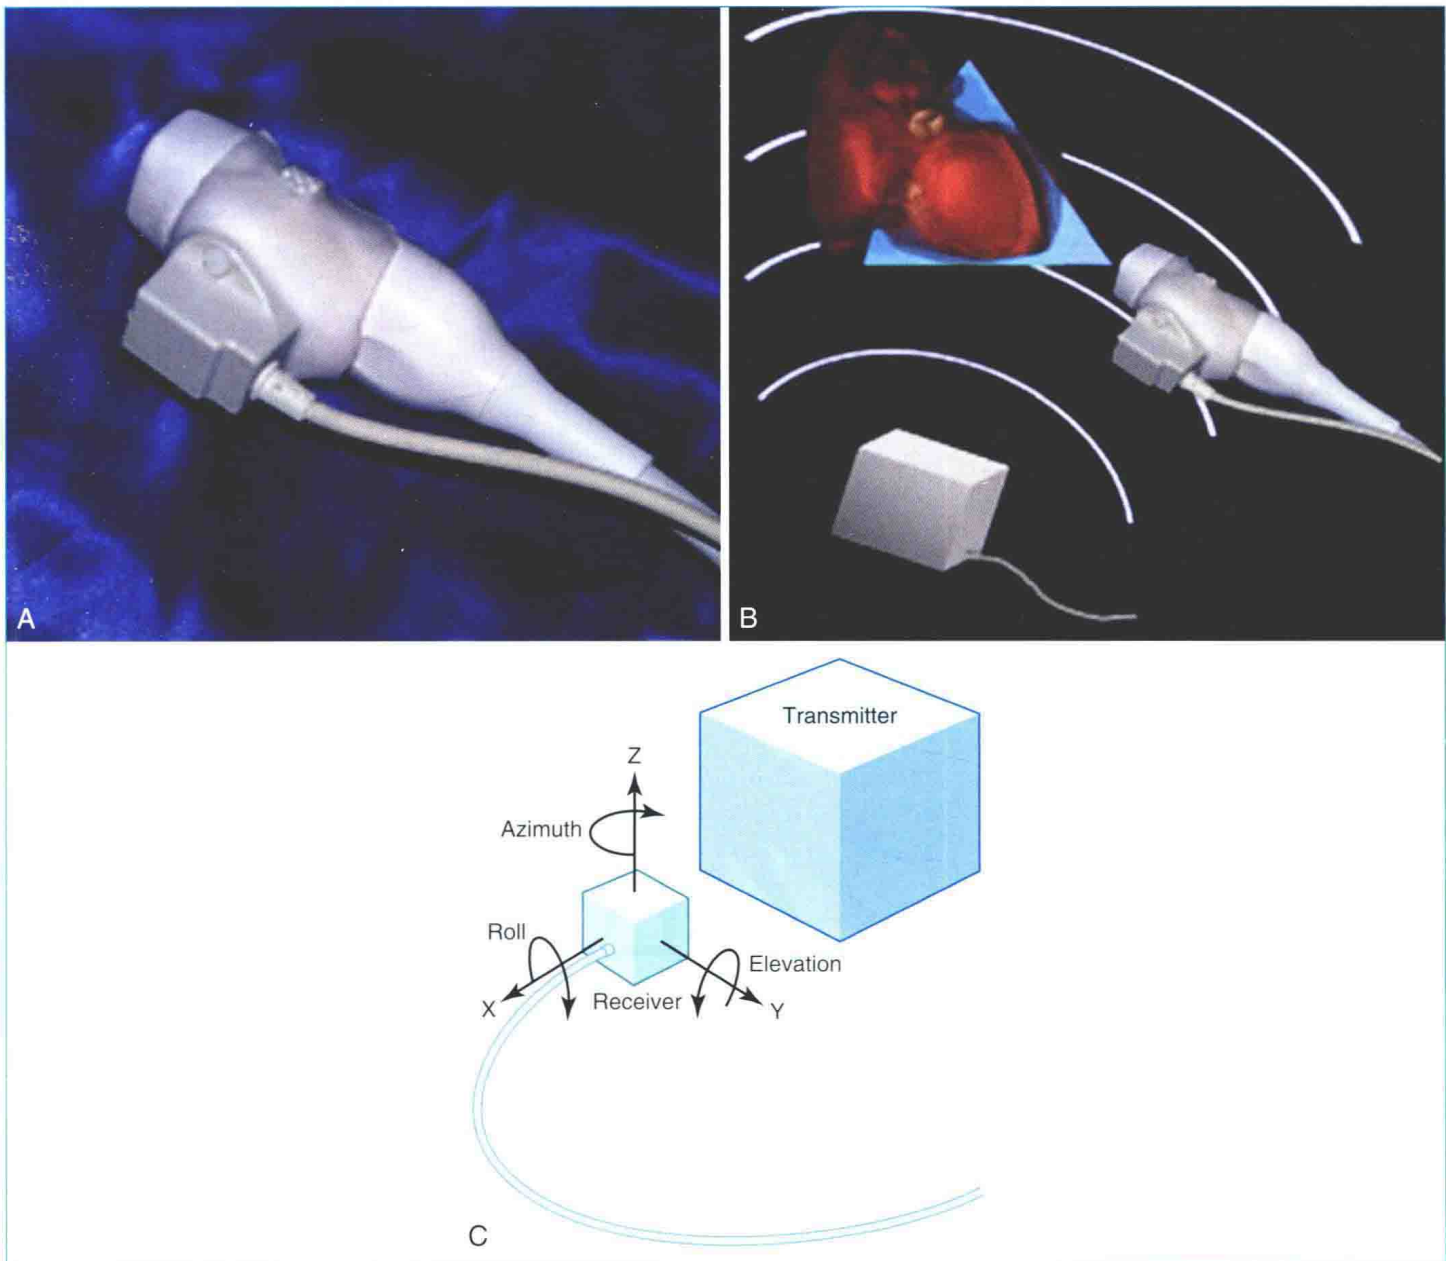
A, Electromagnetic locator device. The sensor is shown attached to a holder for the transducer. B, Summary of the electromagnetic sensor system. The magnet is located in the box, which serves as the transmitter. The magnet is connected to the sensor and indirectly to the ultrasound system. C, The location of the transducer is tracked by the electromagnetic sensor.
